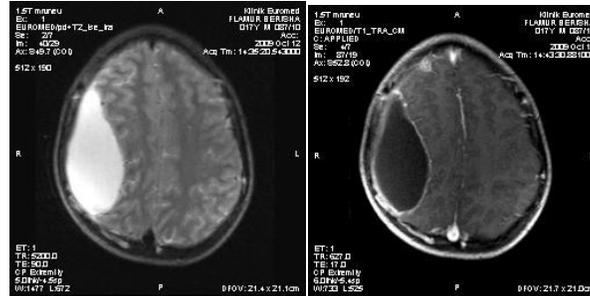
MRI images of subdural empyema.
